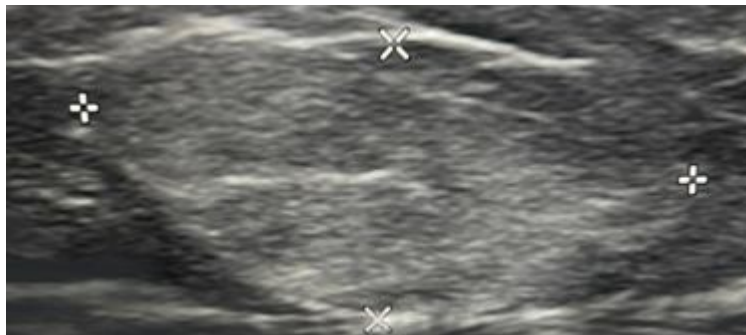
Lipoma: Ultrasound appearance.
